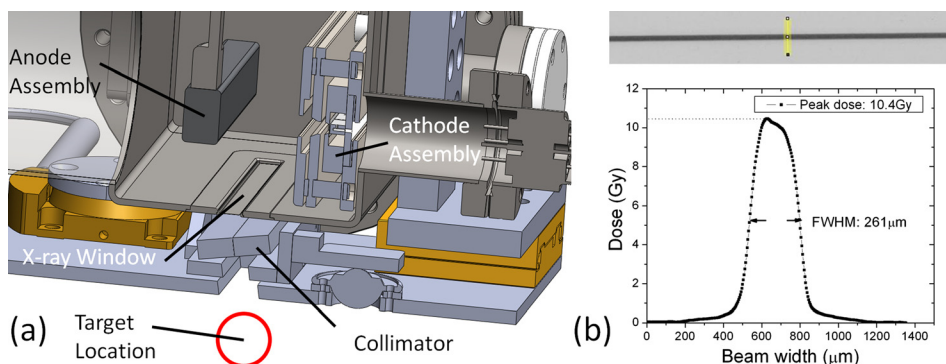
(a) SolidworksTM cross section of the entire device design displaying the target location beneath the anode, X-ray window, and collimator assemblies. (b) Sample irradiated film and beam profile displaying the peak dose achieved in 8 min of irradiation and width of the microbeam created.
